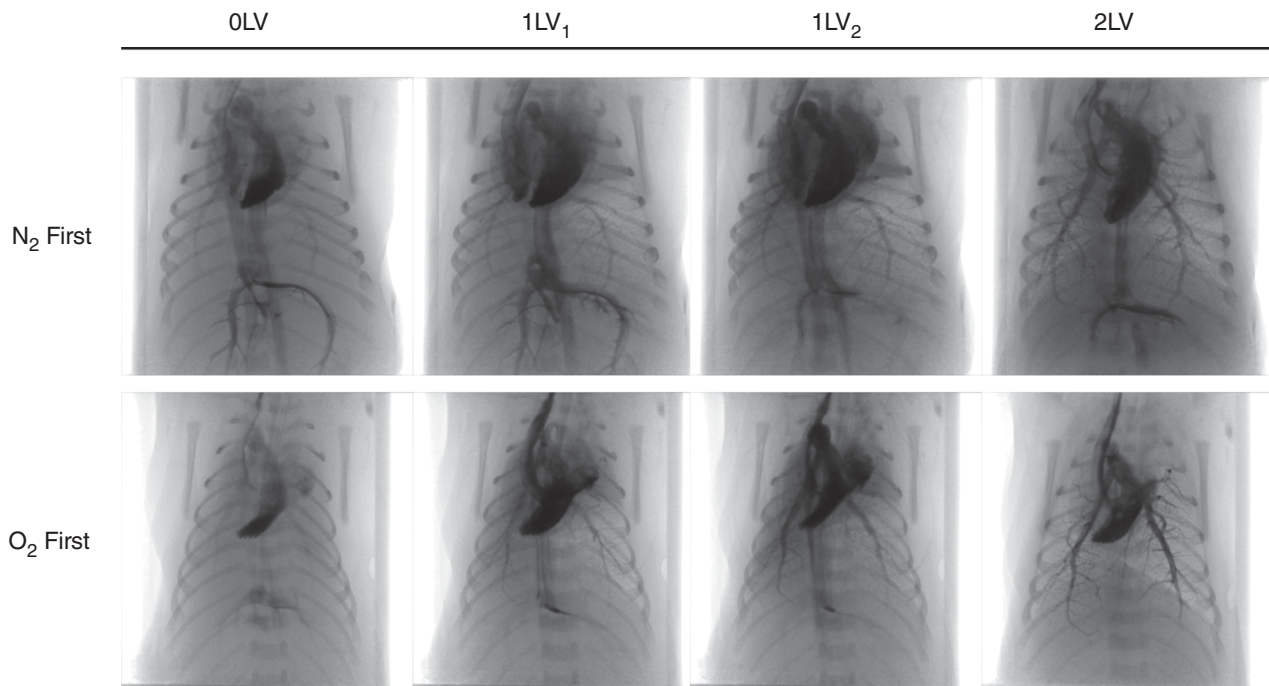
PC X-ray and angiography images
